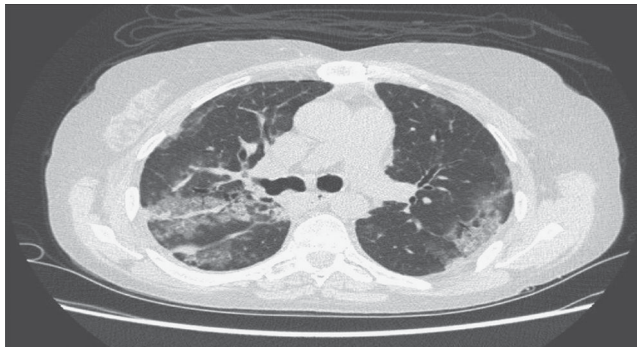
Chest computed tomography scan demonstrating patchy bilateral peribronchial and bronchovascular consolidations.
